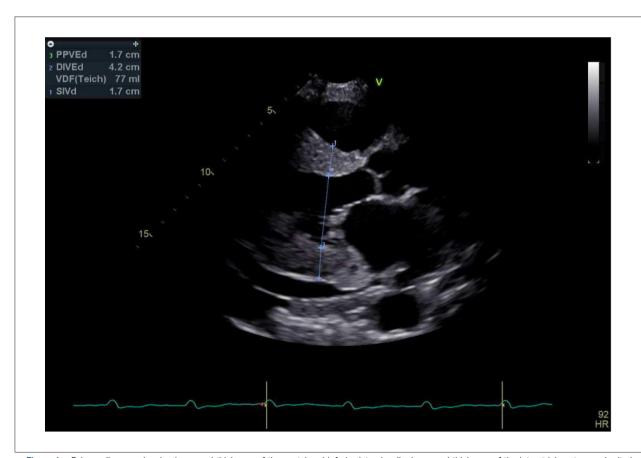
Echocardiogram showing increased thickness of the septal and inferior lateral walls, increased thickness of the interatrial septum and mitral and aortic valves, and pericardial effusion.
